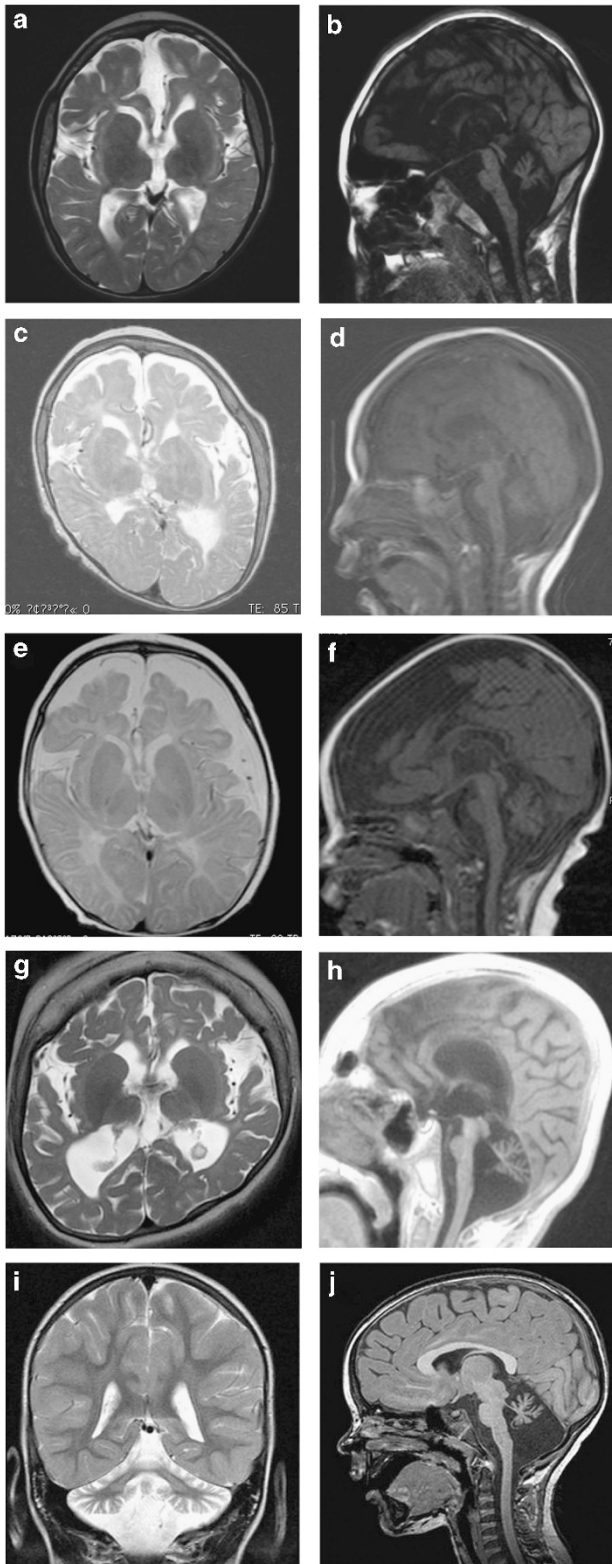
Brain MRI of subjects with *SPTAN1* mutations. T2-weighted axial and T1-weighted mid-sagittal images of subject 1 (a, b), subject 2 (c, d), subject 5 (e, f), subject 6 (g, h) and T2-weighted coronal and T1-weighted mid-sagittal images of subject 7 (i, j). Severe hypomyelination, hypoplasia of corpus callosum, cortical atrophy, and atrophy of brainstem and cerebellum are evident in subject 1, 2, 5 and 6. Only atrophy of brainstem and cerebellum are observed in subject 7.²³ Images of i and j are adapted from ref. 23.
